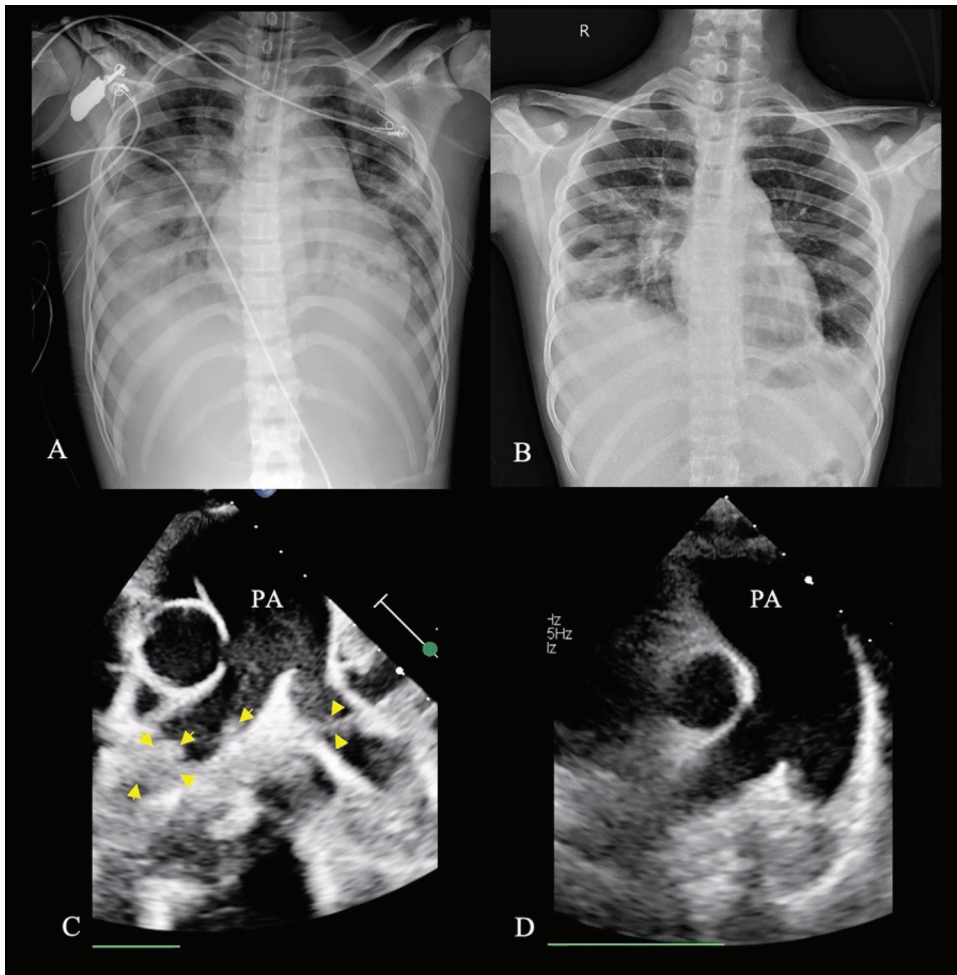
Chest radiograph of the patient on admission (A) demonstrated consolidation with cavitations prominent at both lower lungs, blunt costophrenic angles, and cardiomegaly. Chest radiograph on the discharge day (B) demonstrated cavities at right lower lobe. Echocardiogram in parasternal short axis view of the patient on admission (C) demonstrated multiple hyperechoic masses (arrow heads) on the right and left pulmonary artery. This finding was completely resolved on follow-up echocardiogram before discharge (D).
